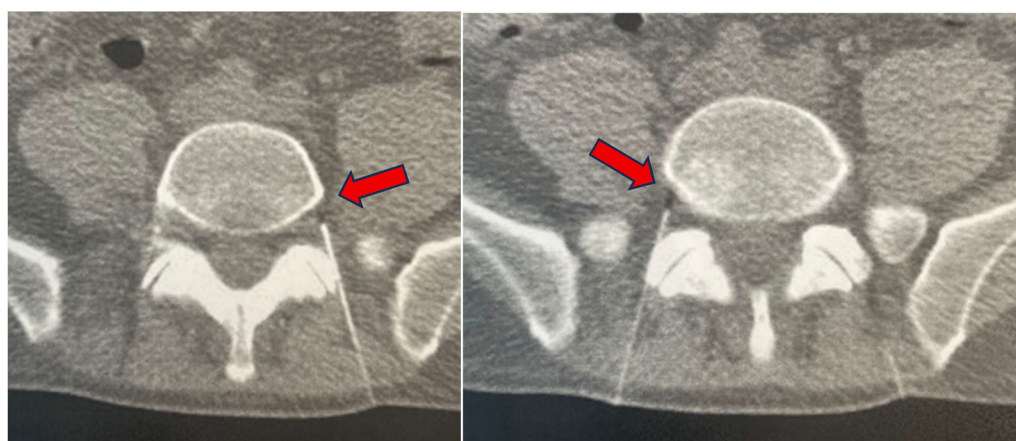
Computed tomography verification of correct needle placement in the periganglionic region (arrows)
